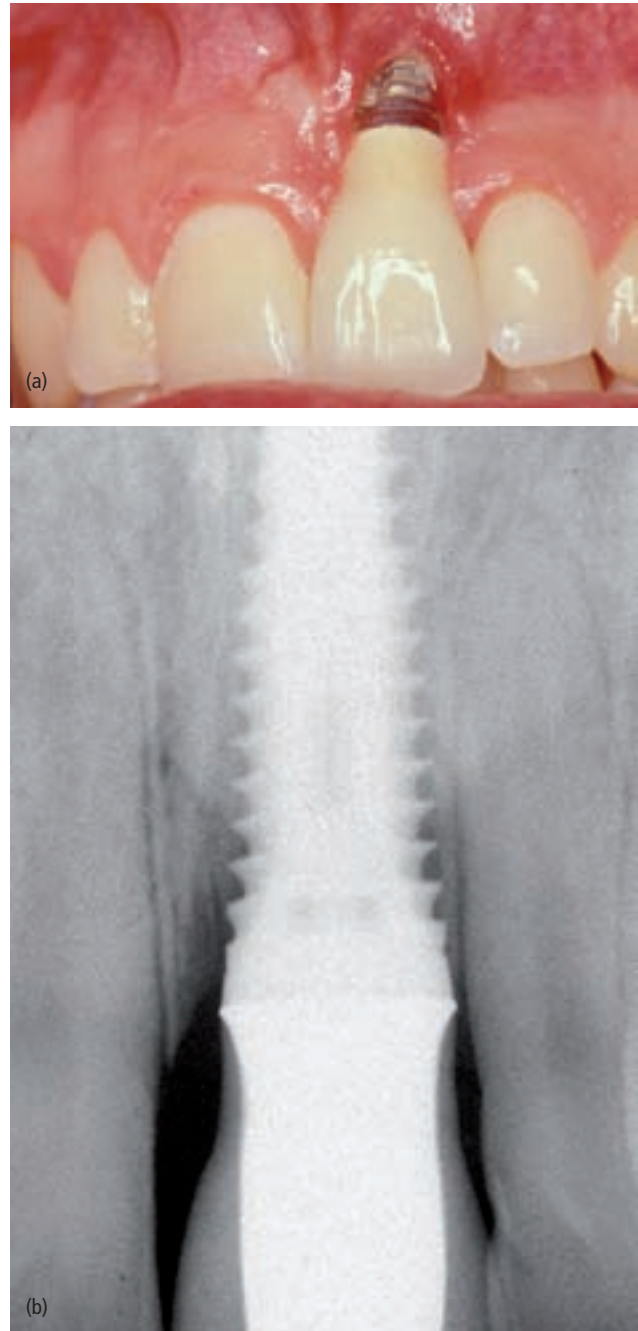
(a) A disaster case with a severe facial recession and an exposed implant surface. The implant, placed as an immediate implant after extraction, is facially and apically malpositioned. (b) The periapical radiograph shows that the inserted, tapered implant was too large. Such a wide platform implant makes a facial malposition even worse.
